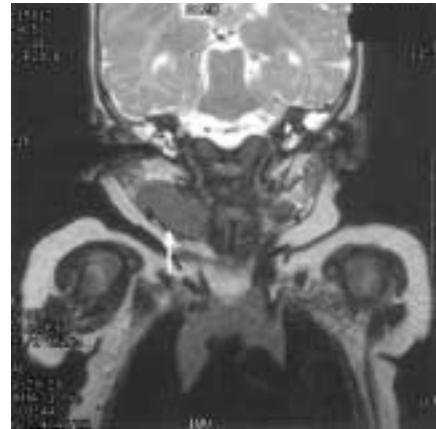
MRI imaging of the tumor. MR T2-weighted coronal image shows right submandibular mass (arrow) with signal intensity identical to that of mediastinal thymus.
